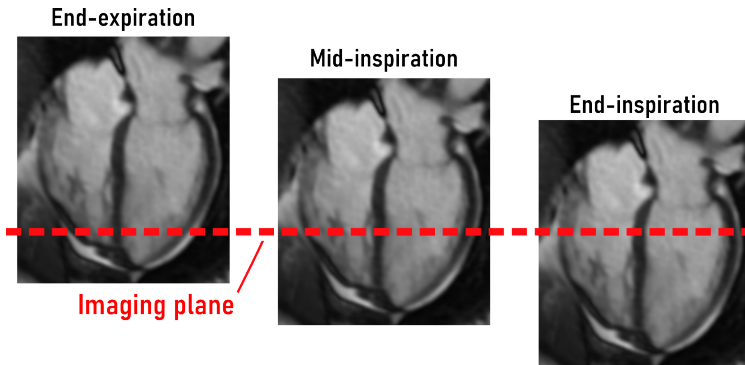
An exaggerated example of how the heart moves through the MR imaging plane when acquiring images during free-breathing.
